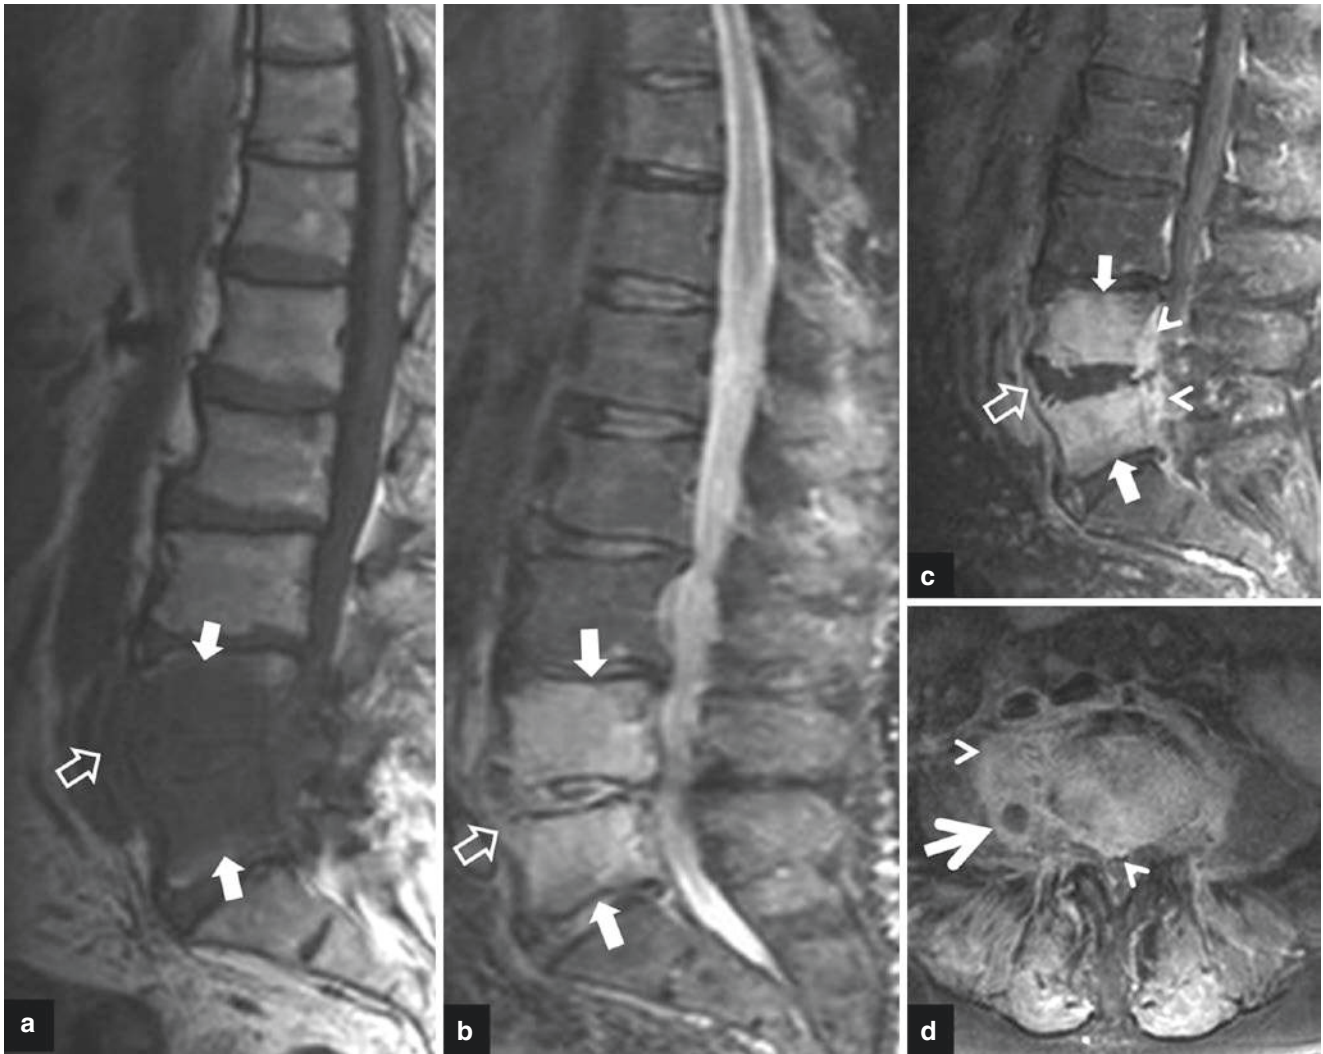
70-year-old male patient with a history of 5 months of low back pain and a final diagnosis of tuberculous spondylodiscitis. MRI with sagittal T1-weighted (a), STIR (b), and contrast enhanced fat suppressed T1 on sagittal (c) and axial (d) planes, show bone marrow
